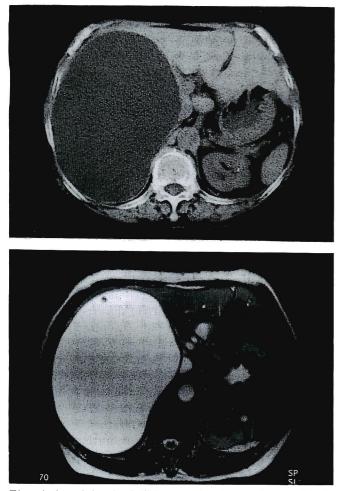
An abdominal CT scan showing a large simple cyst occupying most of the right lobe of the liver (top) and a T2-weighted MRI revealing similar findings to that of the CT scan (bottom).
